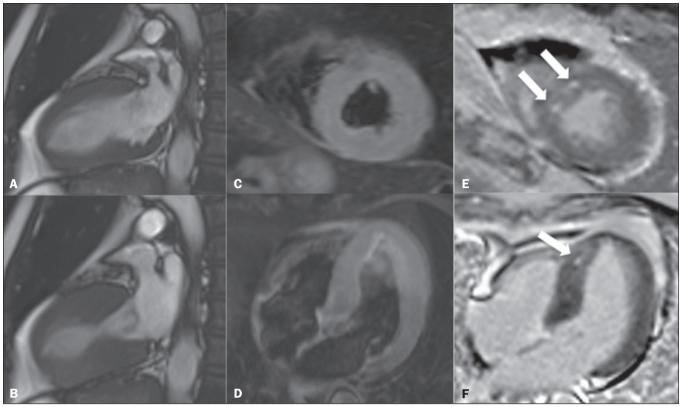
CMR examination of a 66-year-old male patient with typical segmental changes in contractility in cine-SSFP sequences in two-chamber views (A,B), midapical myocardial edema in the LV on the T2-weighted images in a short-axis view (C) and four-chamber view (D), together with small foci of delayed enhancement with a non-ischemic pattern, indicated by the arrows in the short-axis view (E) and four-chamber view (F).
